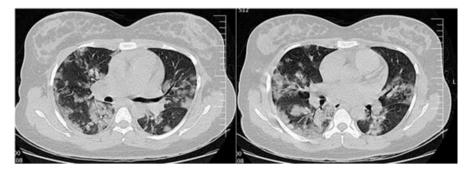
Two axial chest CT scans without contrast showing bilateral and multifocal patchy consolidation in a patient with COVID-19 pneumonitis
